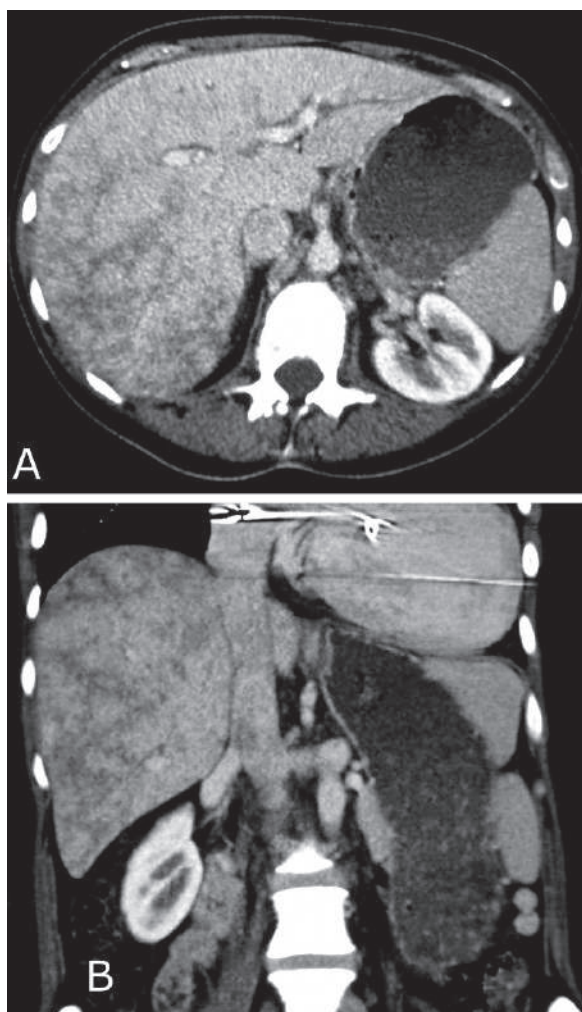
Axial (a) and coronal (b) contrast-enhanced CT in a patient with right-sided heart failure due to tricuspid regurgitation shows the characteristic reticulo-mosaic pattern of enhancement of hepatic venous congestion
